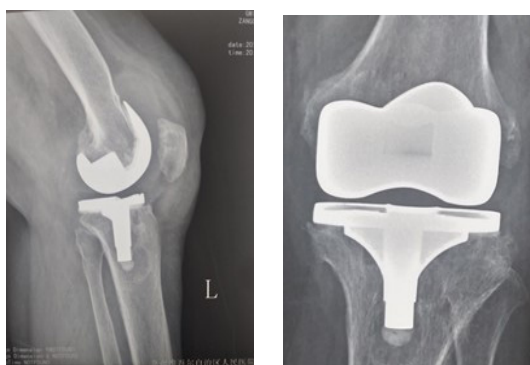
Pre-operation X-ray showed prosthesis loosening
